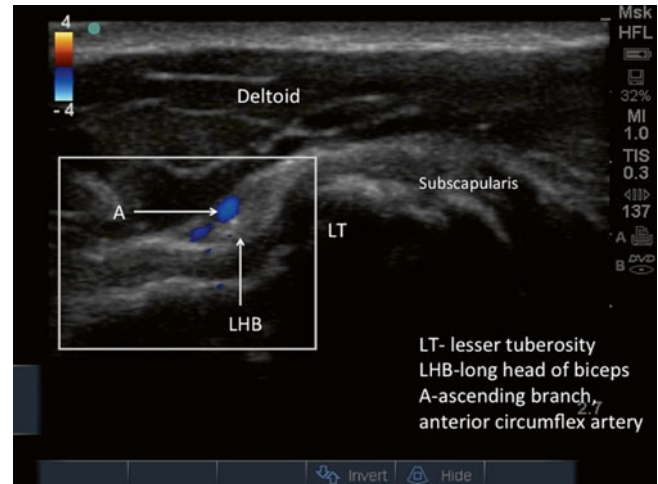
Doppler scan of the long head of biceps which shows the ascending branch of anterior circumflex artery (Reproduced with permission from Philip Peng Educational Series)
